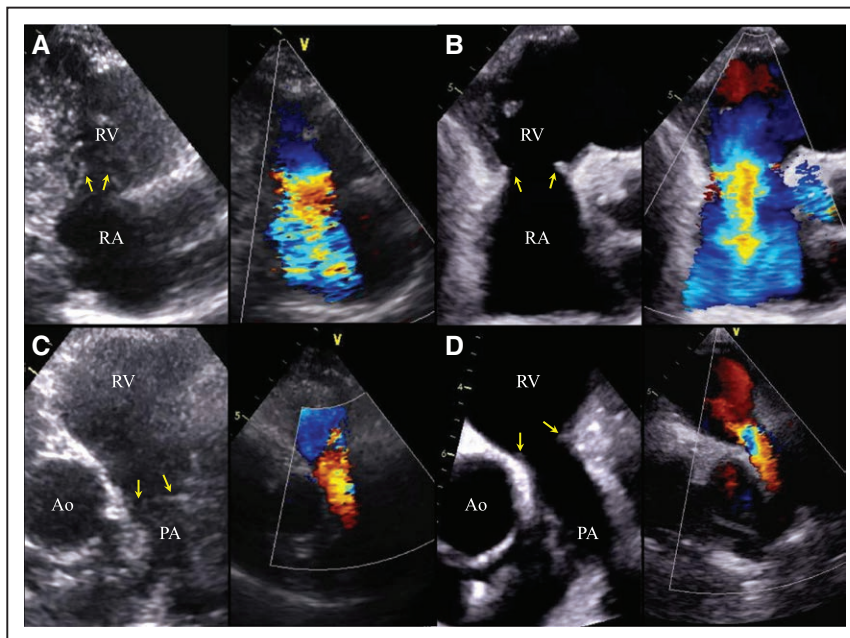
The time-course of changes in the echocardiograms of the right-sided heart valves. A and C, Tricuspid and pulmonary valves recorded 6 years earlier (arrows). B and D, Tricuspid and pulmonary valves recorded on admission (arrows). Left, The B-mode image; and right, the color Doppler image. Ao indicates aorta; PA, pulmonary artery; RA, right atrium; and RV, right ventricle.
